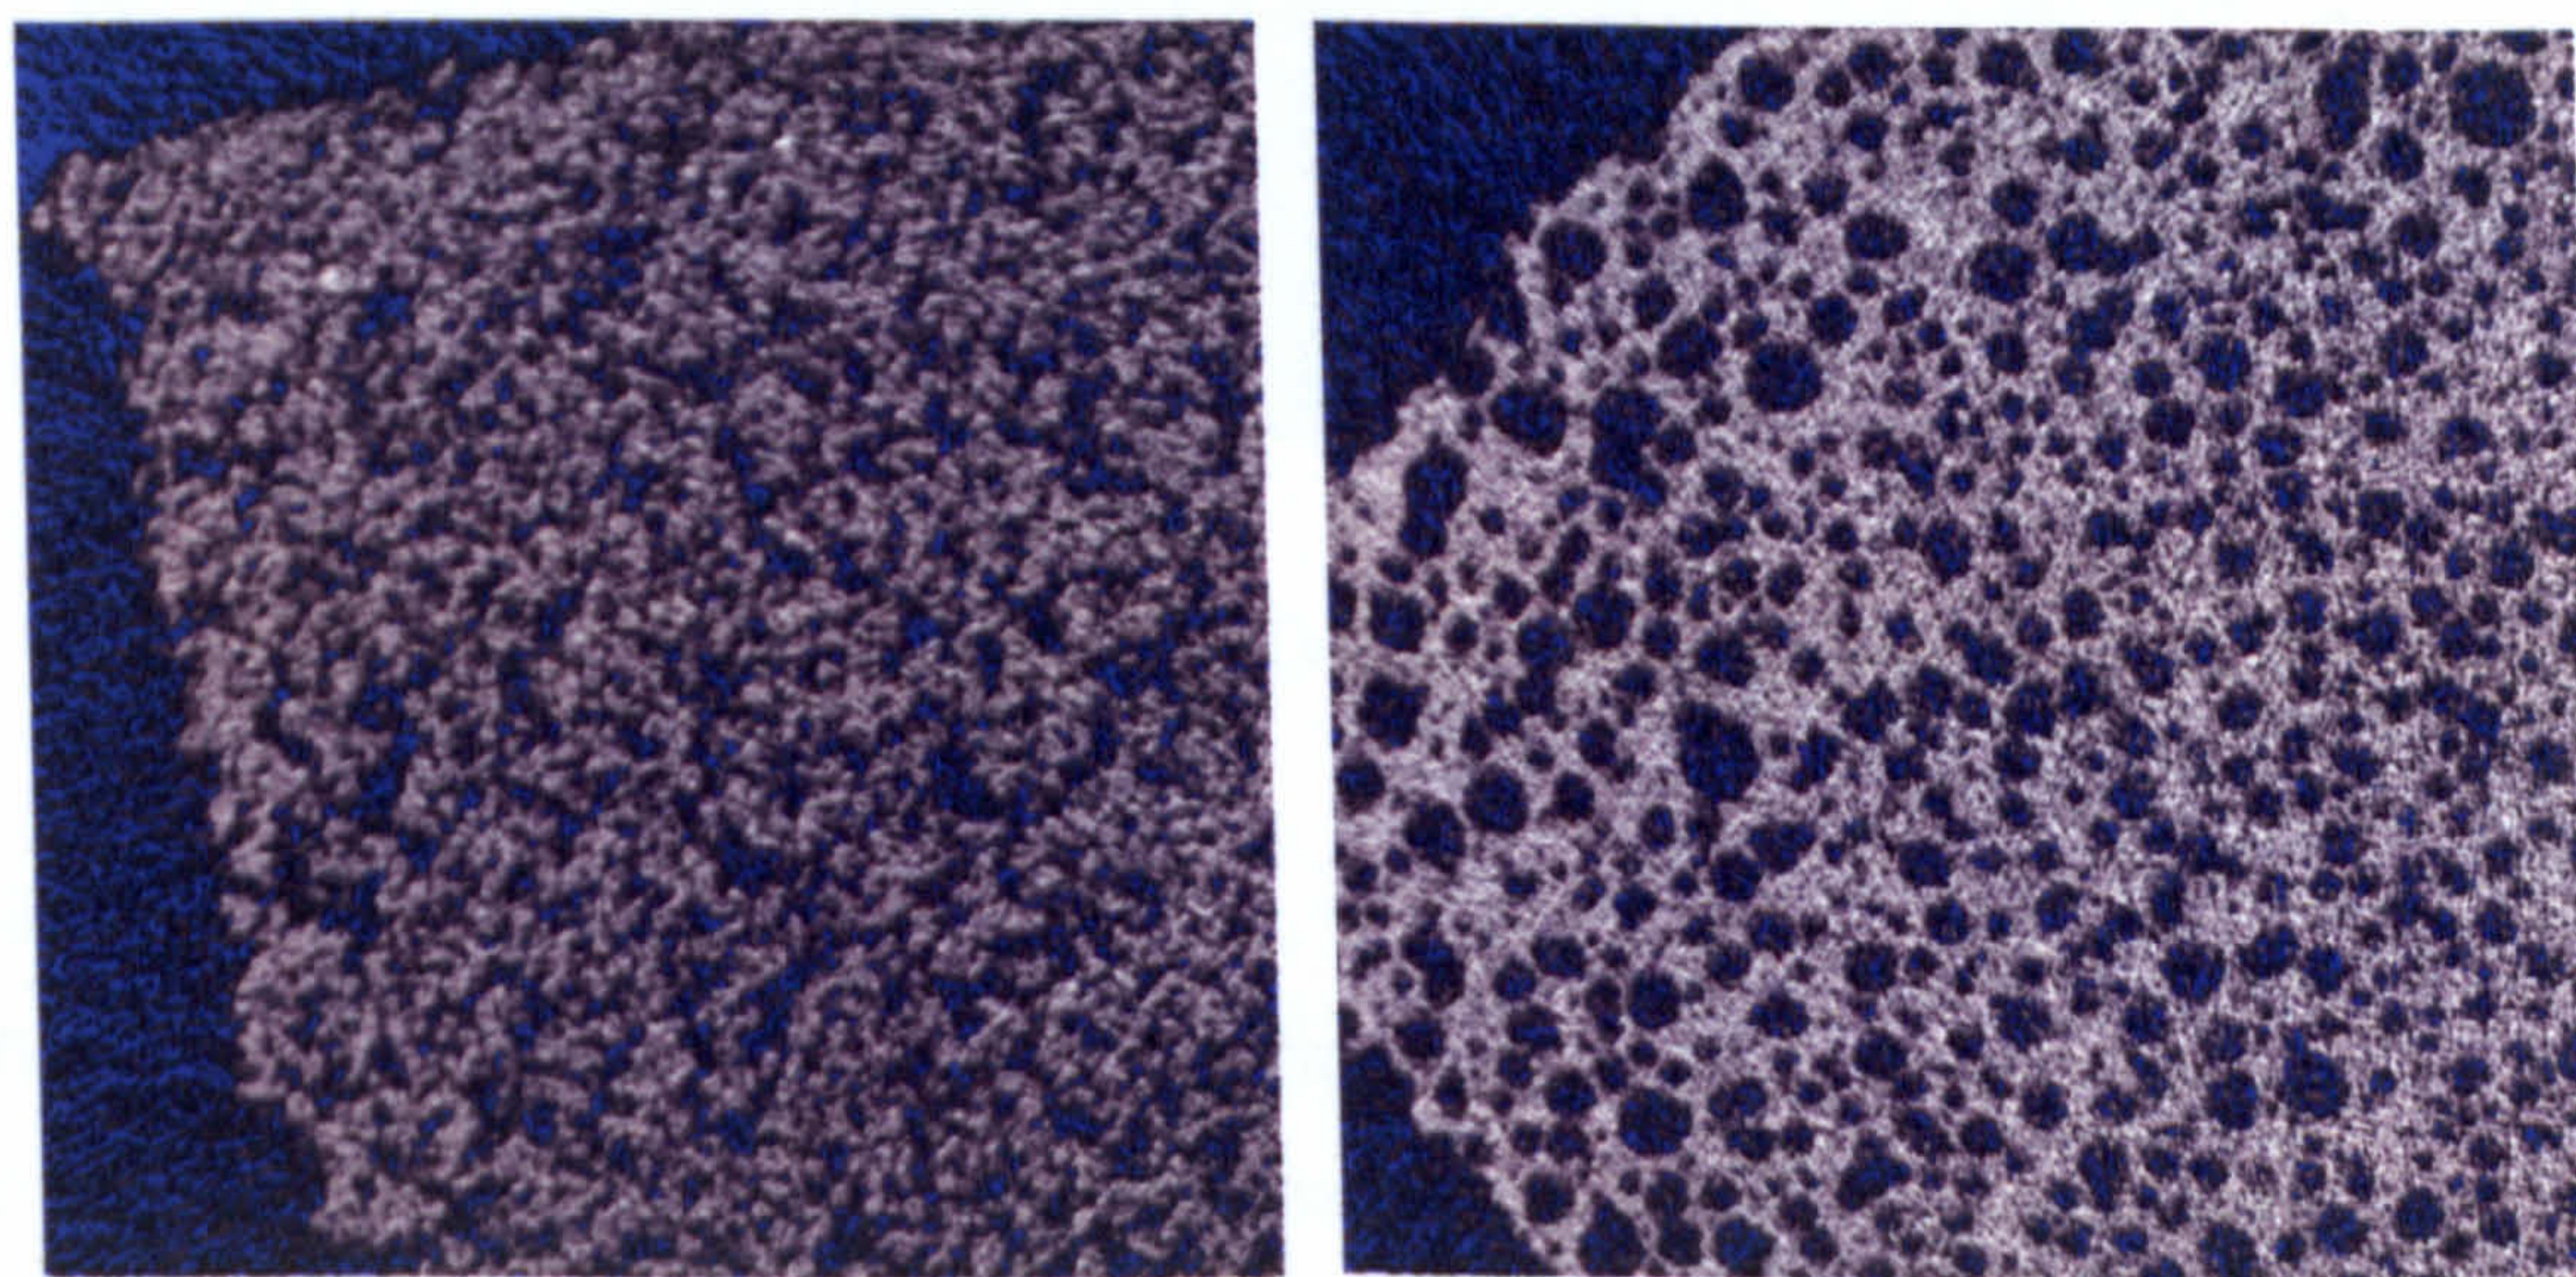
Comparison of  $\mu$ CT scans of LDIG105 before and after infiltration with phosphate glass at  $900^{\circ}\text{C}$ .
